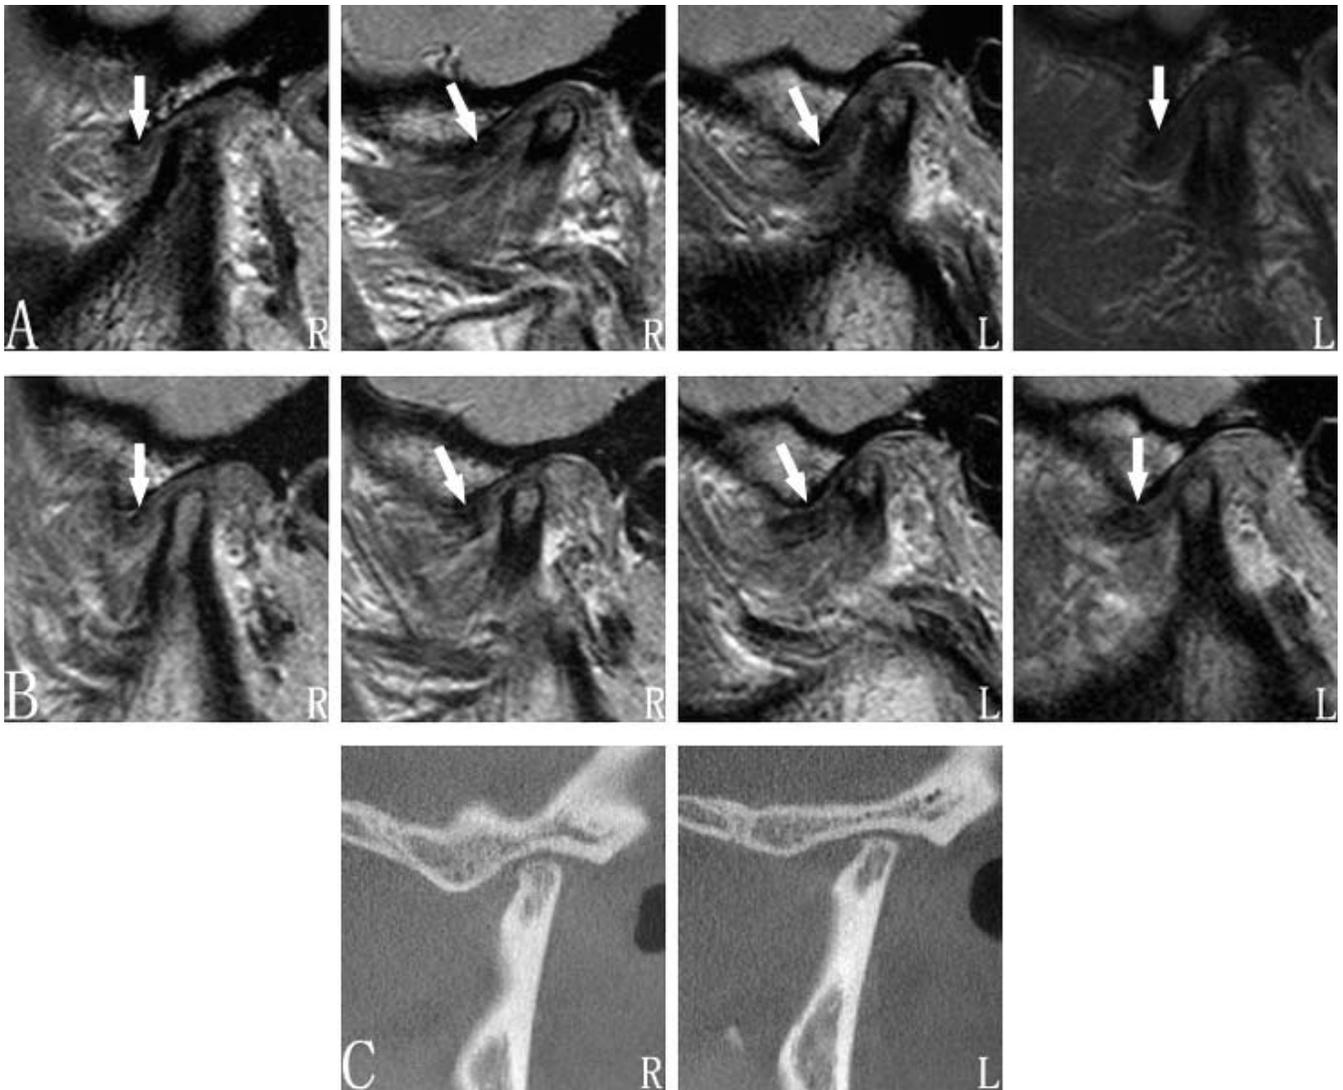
Posttreatment MRI (proton density-weighted images) and CBCT of TMJs: (A) disc (arrow) at both TMJs in oblique sagittal view of closed-mouth position on MRI; (B) disc (arrow) at both TMJs in oblique sagittal view of open-mouth position on MRI; (C) CBCT of both TMJs (R indicates the right TMJ; L, the left TMJ).
